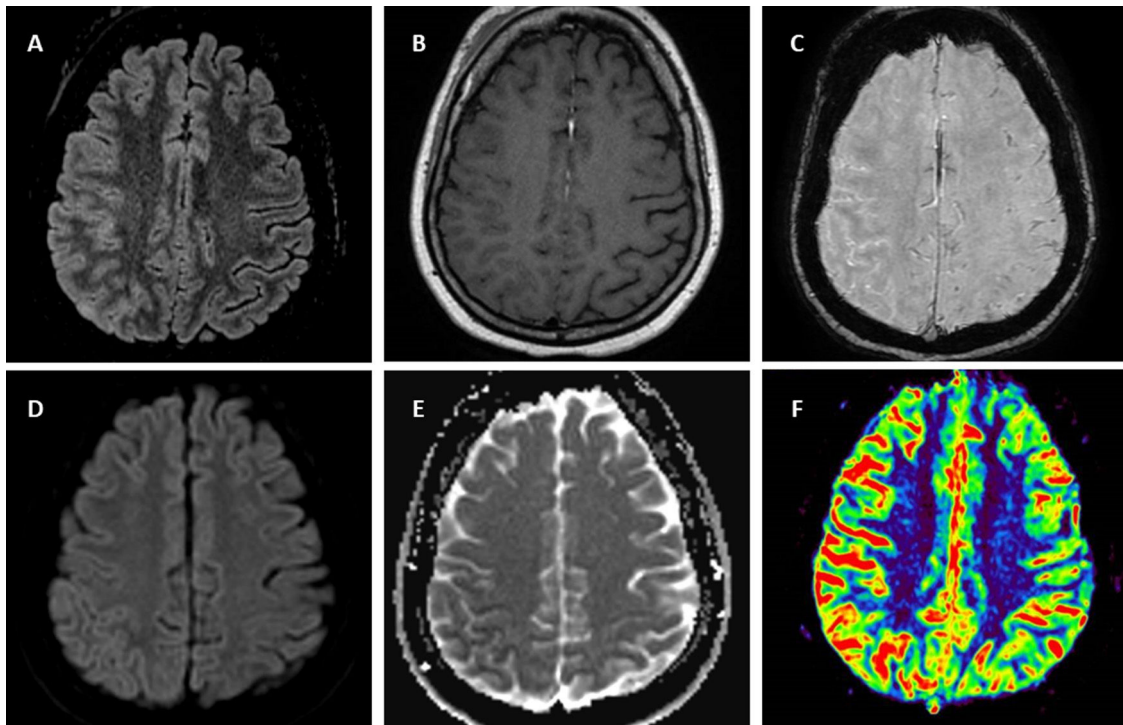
Brain 1.5T MRI of FLAIR-hyperintense Lesion in Anti-MOG-associated Encephalitis with Seizures. T2-fluid attenuated inversion recovery (FLAIR) imaging showing right parietal cortical gyri and some sulci hyperintensity and swelling without involvement of adjacent juxta-cortical white matter (A). Axial T1-weighted post-gadolinium imaging shows right parietal leptomeningeal enhancement (B). Axial susceptibility weighted imaging shows hyperintense vessels in the same region due to decreased oxygen extraction secondary to hyperperfusion (C) confirmed by perfusion imaging sequences (F). Diffusion restriction in posterior parietal gyri (D,E).
